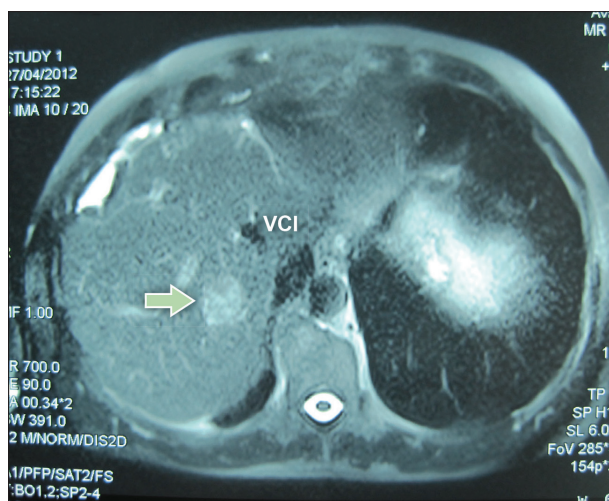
Pretreatment abdominal MRI demonstrating a tumor in liver segment VIII
